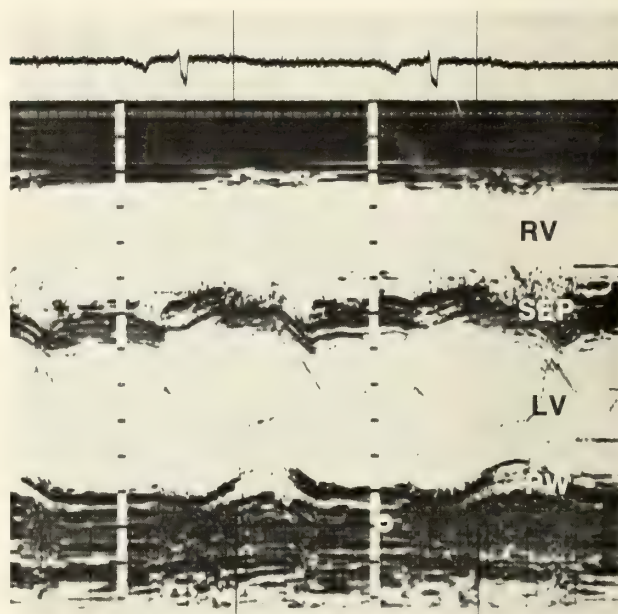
Echocardiogram recorded shortly after admission. Note the normal left ventricular contraction pattern and absence of pericardial thickening or effusion. At this level, with the mitral valve still visible, the apparent paradoxical septal motion may be within normal limits. RV = right ventricular cavity; SEP = interventricular septum; LV = left ventricular cavity; PW = left ventricular posterior wall.
